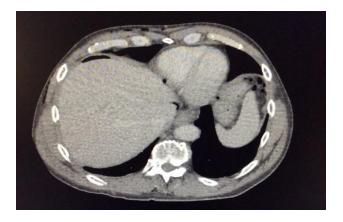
CT abdomen and pelvis with contrast, axial view showing pneumoperitoneum.
